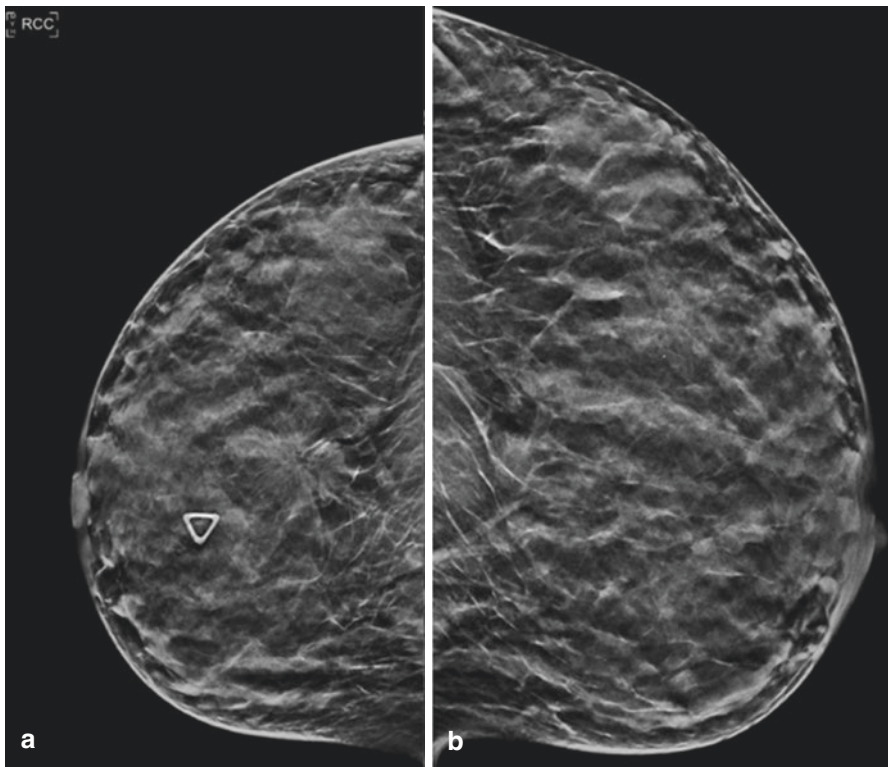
(a) Right CC view. (b) Left CC view. (c) Right MLO view. (d) Left MLO view. (e–g) Axial post-contrast breast MRI. (e) Maximum intensity projection MRI. (f, g) Axial fat suppressed T1 post-contrast. (h, i) Sagittal post-contrast MRI. (h) Right breast. (i) Left breast
